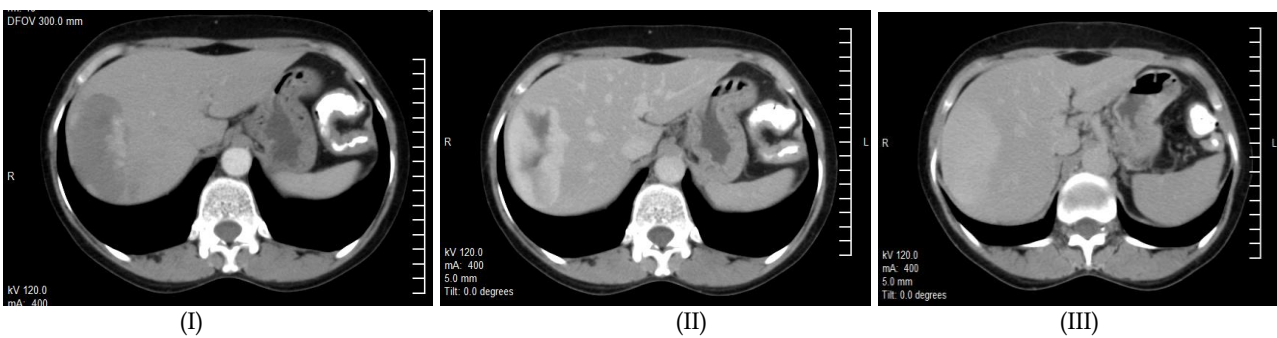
Showing Arterial phase CT scan shows peripheral nodular enhancement (black arrow) (I), Portal venous phase shows centripetal extension (II) and shows diffuse enhancement in equilibrium phase (III).
